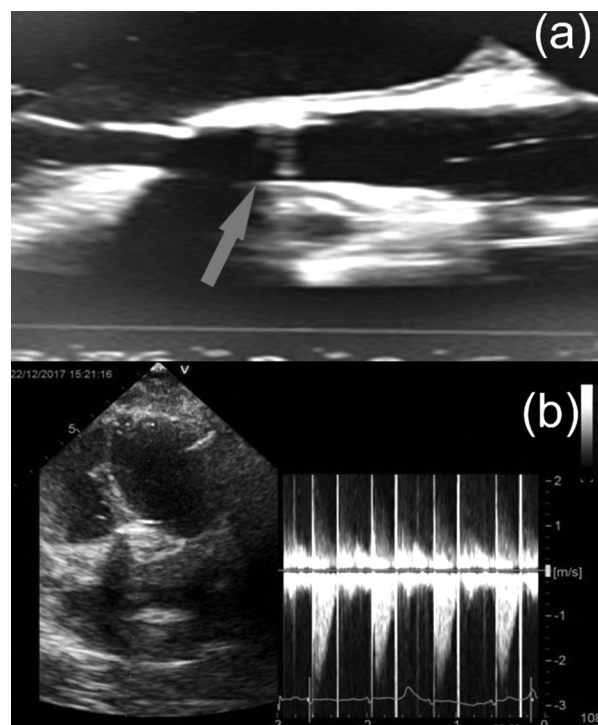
Postoperative echocardiography: a) Transesophageal echocardiography shows normal excursions of mechanical aortic valve leaflets (arrow points to the prosthetic aortic valve); b) Transthoracic echocardiography shows a normal gradient across the prosthesis
